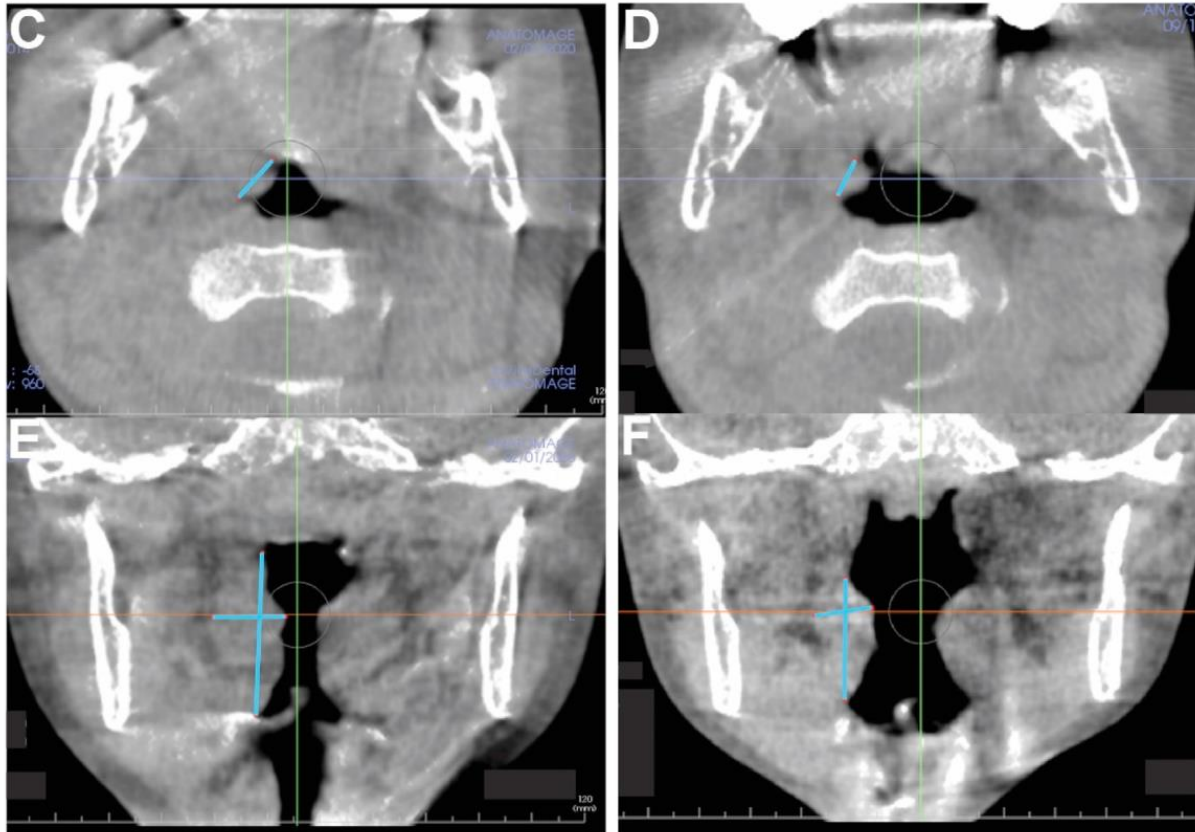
Representative CBCT sagittal slices of T1 (A) and T2 (B) for adenoid volume changes
